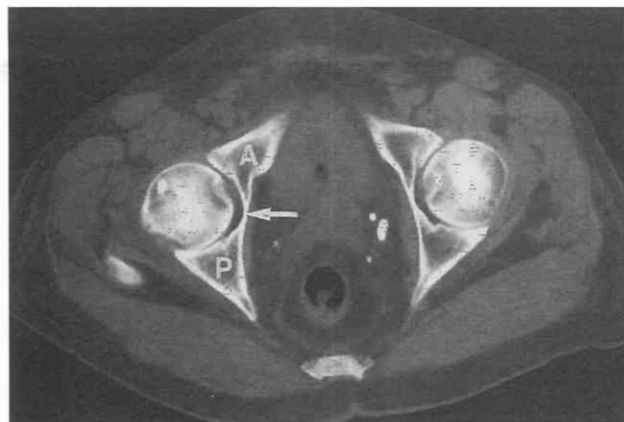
Normal anatomy. CT scan through the femoral heads shows anterior column (A), quadrilateral plate (arrow), and posterior column (P) of the acetabulum.
